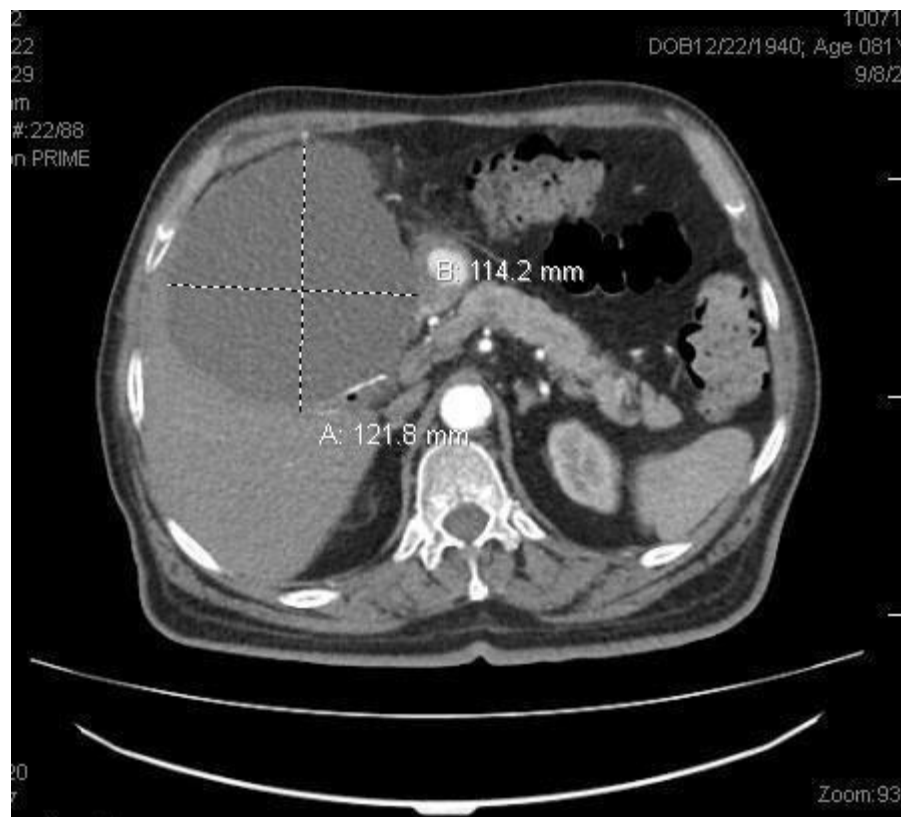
Abdominal CT scan (axial cut) showing gallbladder fossa abscess measuring 11.4 x 11.5 x 12.1 cm
